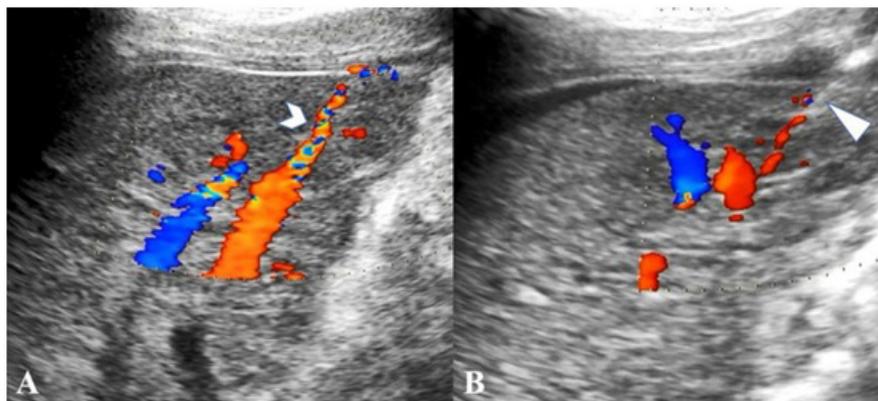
Hemorrhage and embolization of transhepatic trace under ultrasound (US) guidance. (A) Sonogram showed subcapsular outward blood flow (white arrowhead) as a sign of hemorrhage of the transhepatic trace. (B) Needle (white triangle) was accessed along the blood flow (white arrowhead) for compression hemostasis under US guidance.
